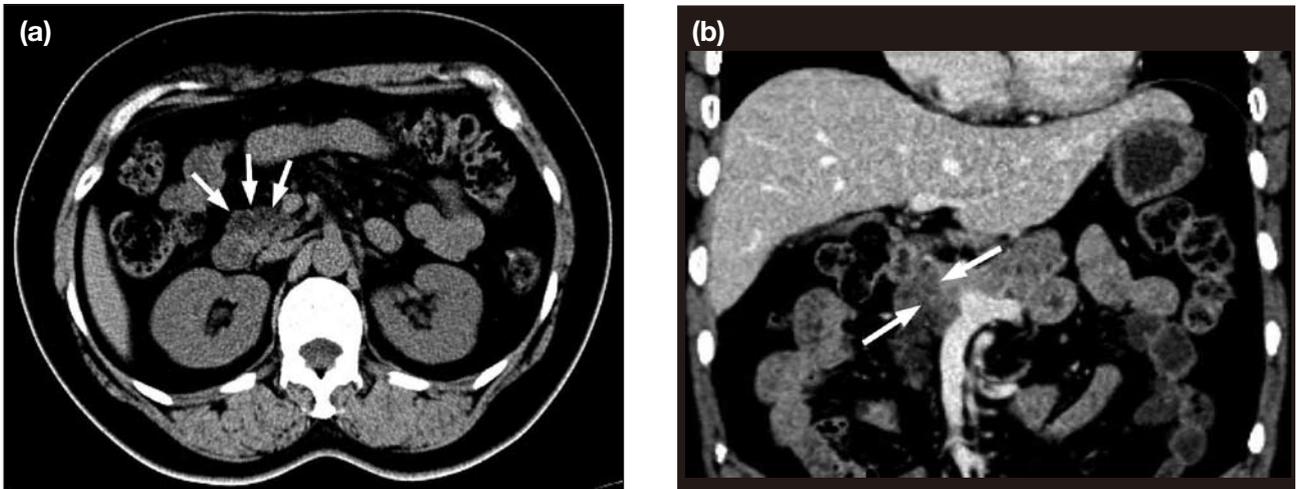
Computed tomography images of the pancreas. (a) Non-contrast computed tomography (axial image) showing a low-attenuation lesion without bulging contours in the head of the pancreas (arrows); and (b) contrast-enhanced computed tomography (coronal reformat images) showing a low-attenuation lesion in the head and uncinate process of the pancreas (arrows) abutting the portal and superior mesenteric vein, with no evidence of vascular encasement.
